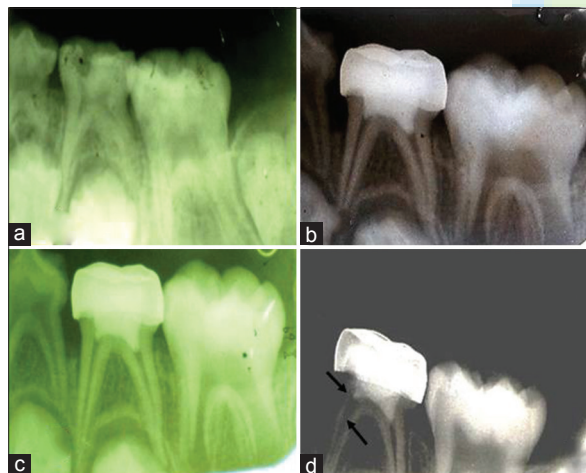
(a). preoperative radiograph of FC treated tooth (b) 6 months follow-up (no signs of failure) (c) 9 months follow-up (d) At 12 months follow-up (internal root resorption)
